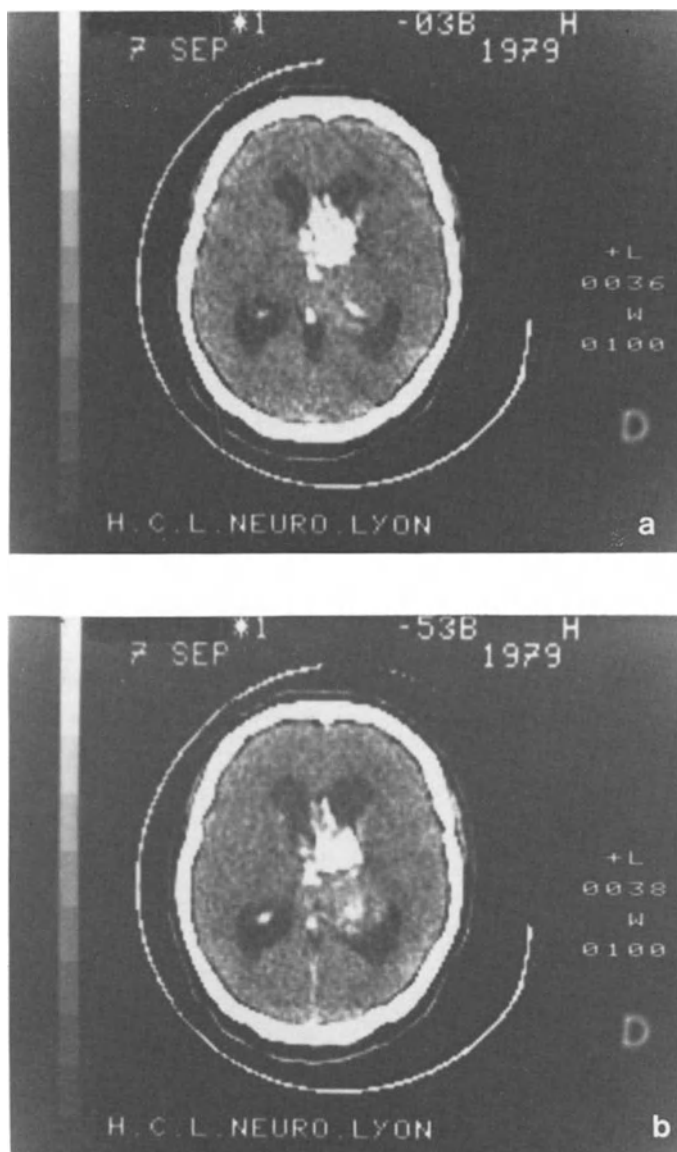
Calcified oligodendroglioma. a) Pre-contrast CT. b) Post-contrast CT: slight enhancement
